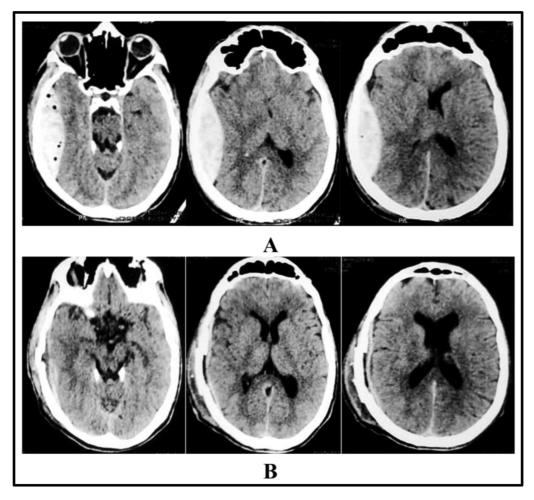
(A, B) Adult patient presented 2 hours after road traffic accident with Glasgow Coma Scale (GCS) 8/15. (A) Initial computed tomography (CT) brain showing right temporoparietal large volume extradural hematoma (EDH) with midline shift. Patient underwent early surgical evacuation of EDH "within the first 6 hours after trauma." (B) Postoperative CT brain showing complete hematoma evacuation with improvement of midline shift. Postoperatively, GCS was improved to 14/15 and the patient had favorable clinical recovery at discharge.
